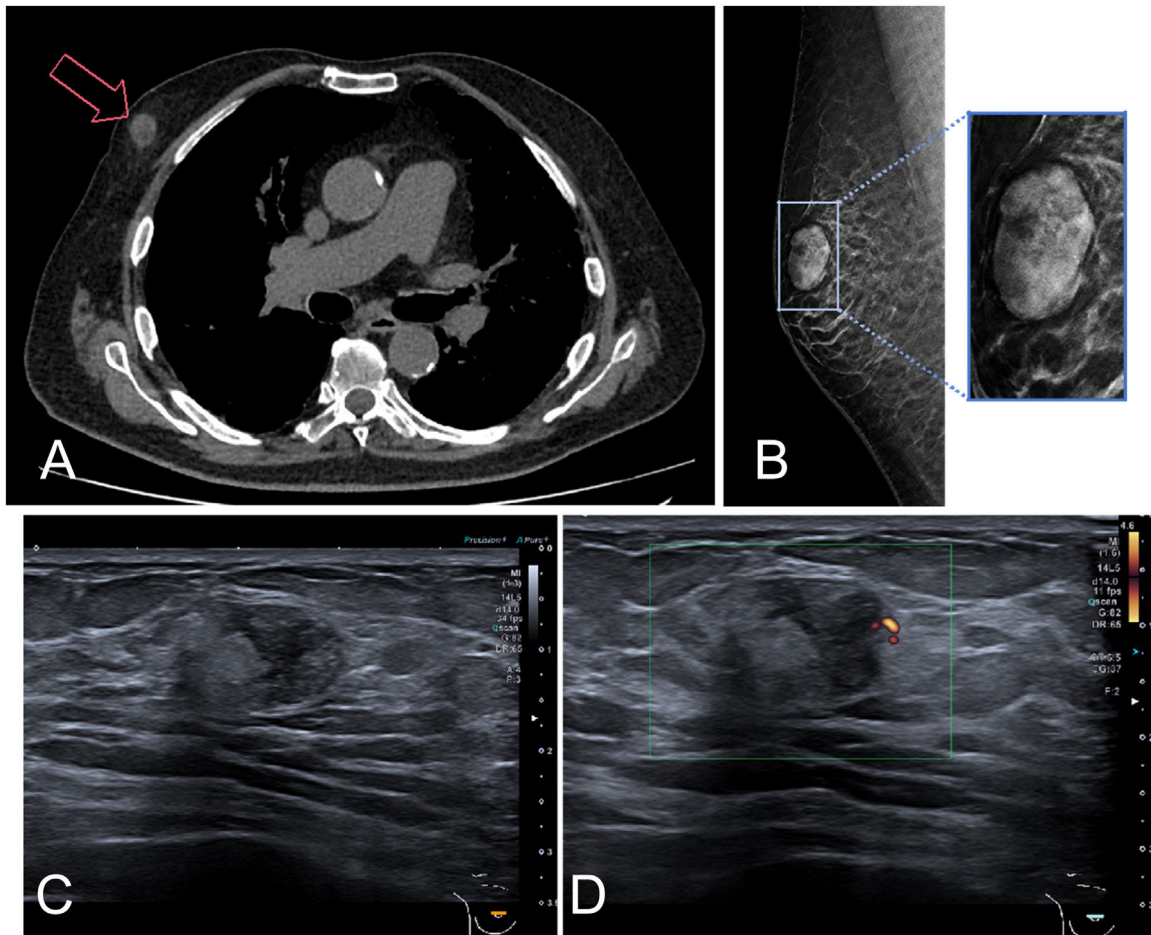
(A) Chest CT shows a 16-mm oval mass in the right breast (arrow). (B) Mediolateral oblique DBT of the right breast shows an oval nodule with circumscribed margins at the 12 o'clock position. (C,D) Echography shows a heterogeneous oval nodule with circumscribed margins with peripheral vascularisation on Doppler evaluation.
